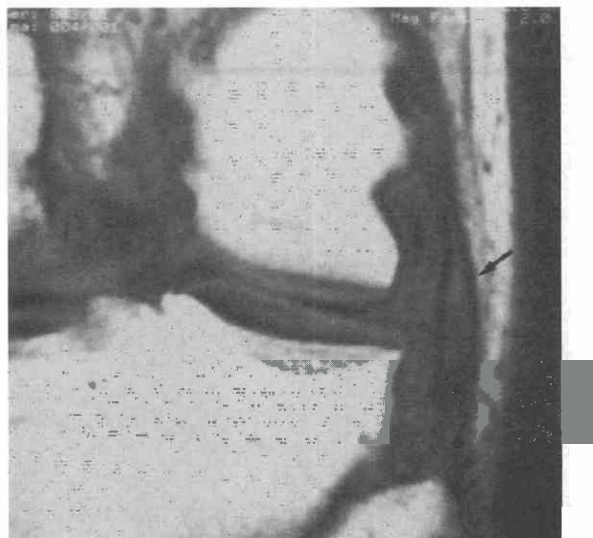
Lateral collateral ligament tear. Coronal T1-weighted image shows intermediate-signal-intensity replacement of the lateral collateral ligament, which is split, redundant, and discontinuous (arrow).
